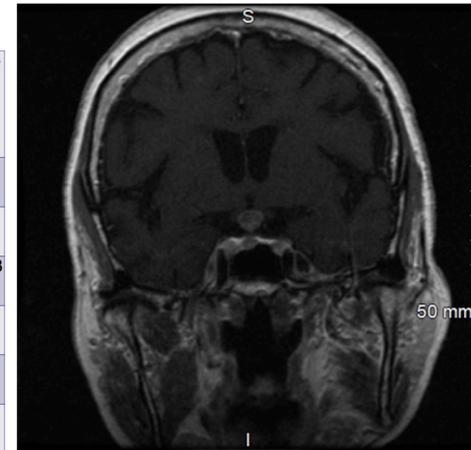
MRI Pituitary Coronal View.
